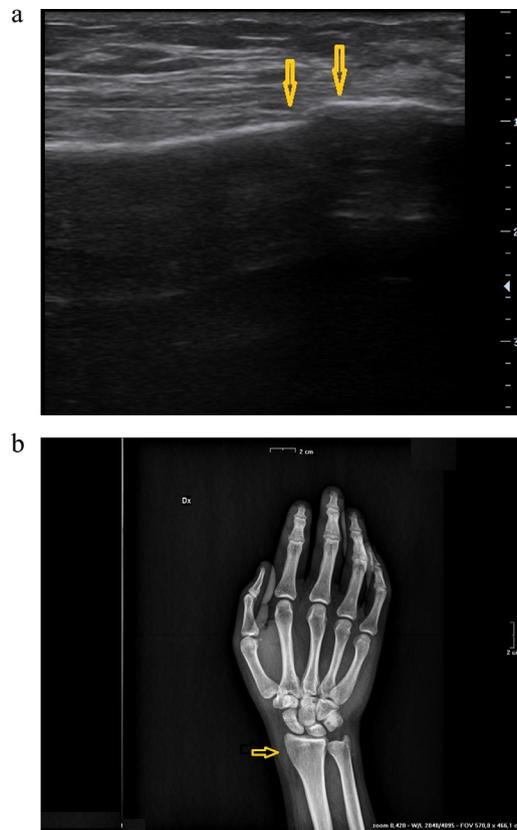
(a) Ultrasound image of distal radius with very small cortical step-off (yellow arrow). (b) X-Ray image of distal radius with very small cortical step-off (yellow arrow).
